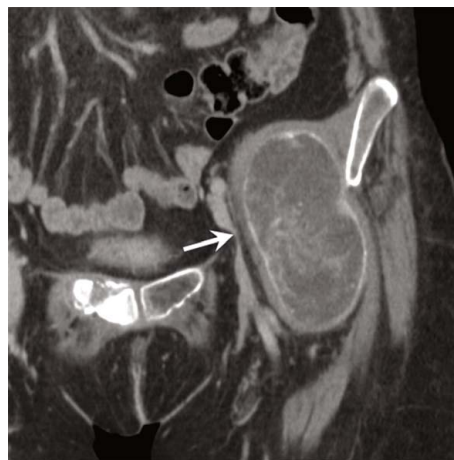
Reformatted computed tomography shows a cystic mass compressing the femoral vein (arrow).
